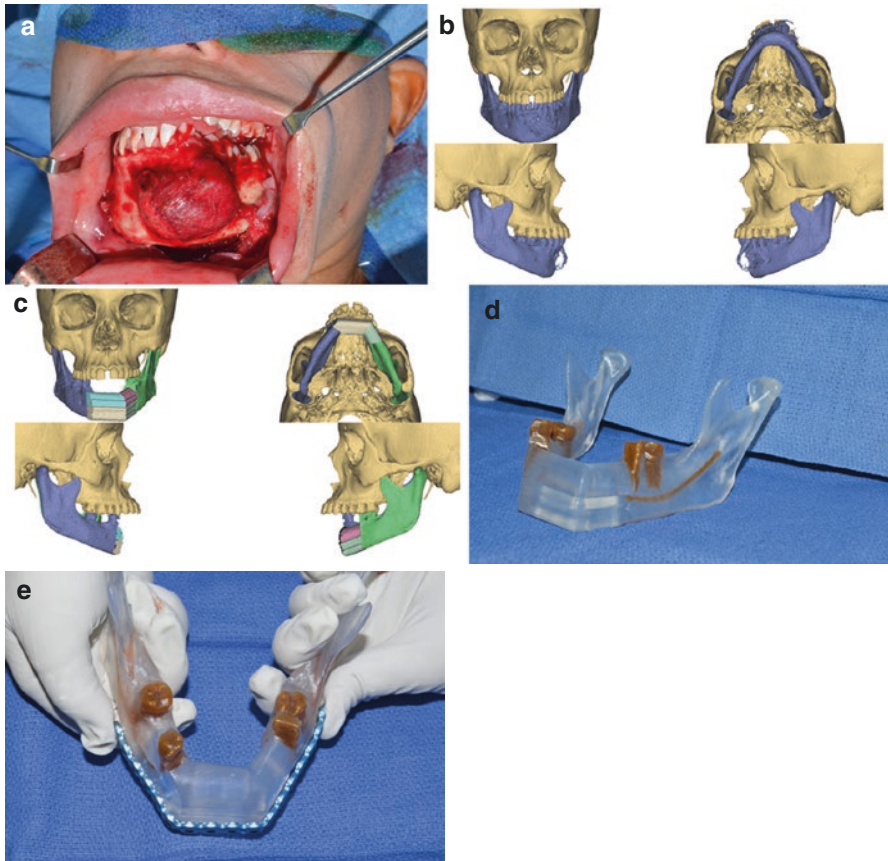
(a) Tumor distorting the outer cortex of the mandible. The plate could not be contoured on the native mandible. (b) 3-D CT reconstruction showing the extent of the tumor with expansion of the outer cortex. (c) Virtual planning of a double barrel free fibula design. (d) Stereolithographic hybrid model was made from the virtual computer planning. (e) The hybrid model was used to prebend the plate
